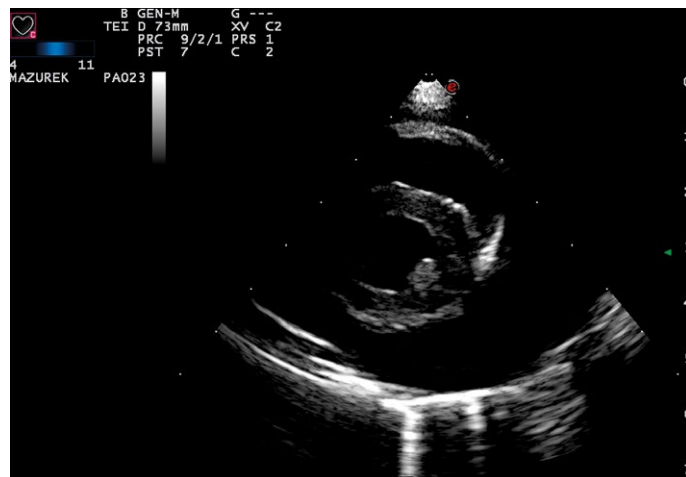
Right-side parasternal short axis view. The left ventricle of the heart was surrounded by liquid in the pericardial sac
